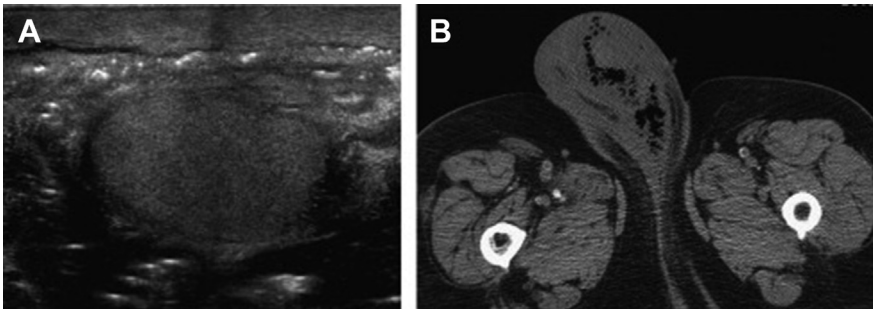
Subcutaneous gas in Fournier gangrene on scrotal ultrasound (A) and CT scan of scrotum (B). (From Mirochnik B, Bhargava P, Dighe MK, et al. Ultrasound evaluation of scrotal pathology. *Radiol Clin North Am* 2012;50(2):319, vi; with permission.)
